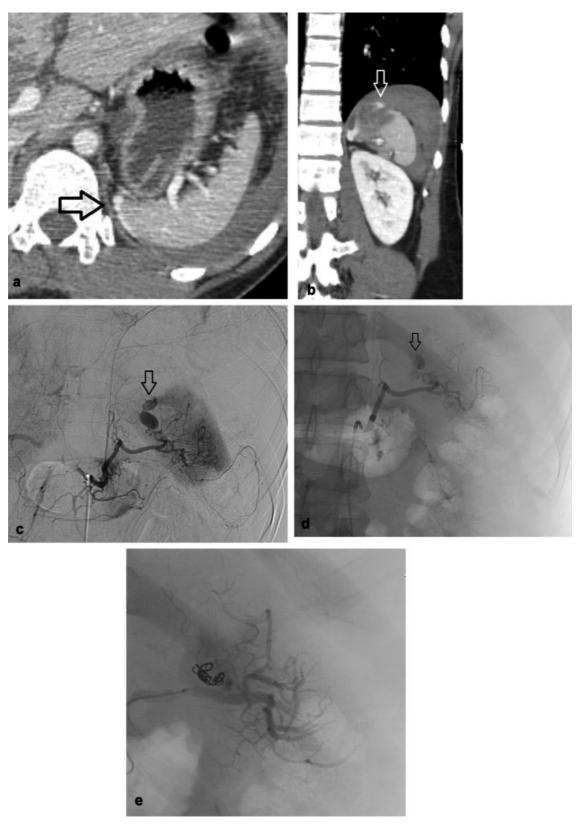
A 29-year-old man involved in motor vehicle crash. (a) Axial CT abdomen and (b) coronal CT abdomen showing small focal laceration along the superior medial aspect of the spleen with extravasation of contrast (*arrow*). (c) Celiac angiography. (d) Splenic angiography demonstrating a pseudoaneurysm along the medial aspect of the spleen with active extravasation into the peritoneum (*arrow*). (e) Embolization of a distal splenic artery branch supplying the pseudoaneurysm was performed with multiple coils and small aliquots of Gelfoam slurry resulting in no flow seen past the area of embolization, no evidence of remaining pseudoaneurysm or extravasation.
